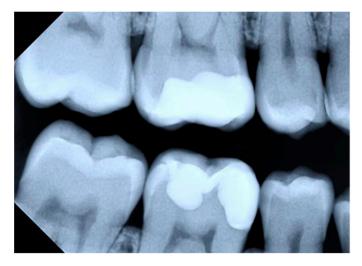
Bitewing radiography.
